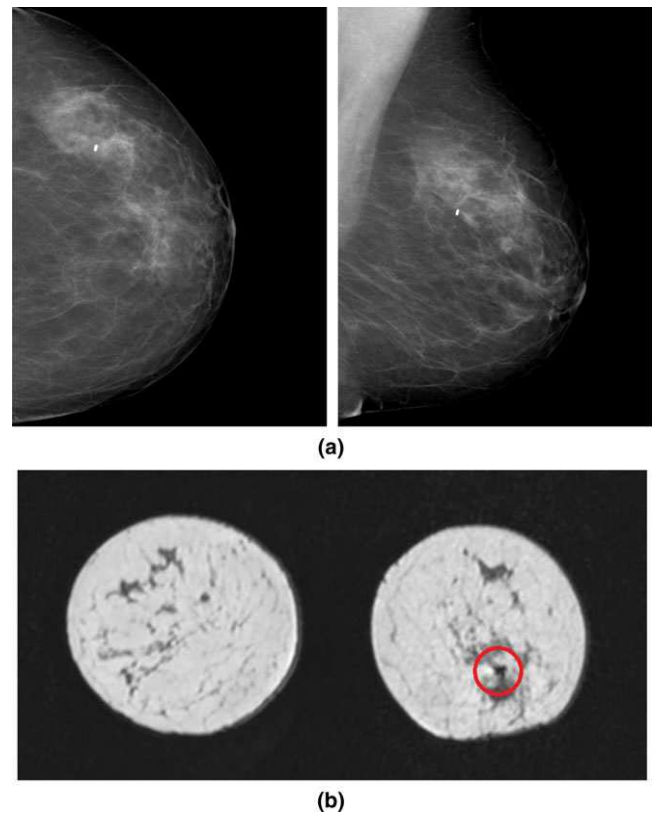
Metallic clip for image-guide biopsy. The clip is visible in (a) CC and MLO mammograms as a bright spot, while (b) in MRI it yields a dark bubble.
